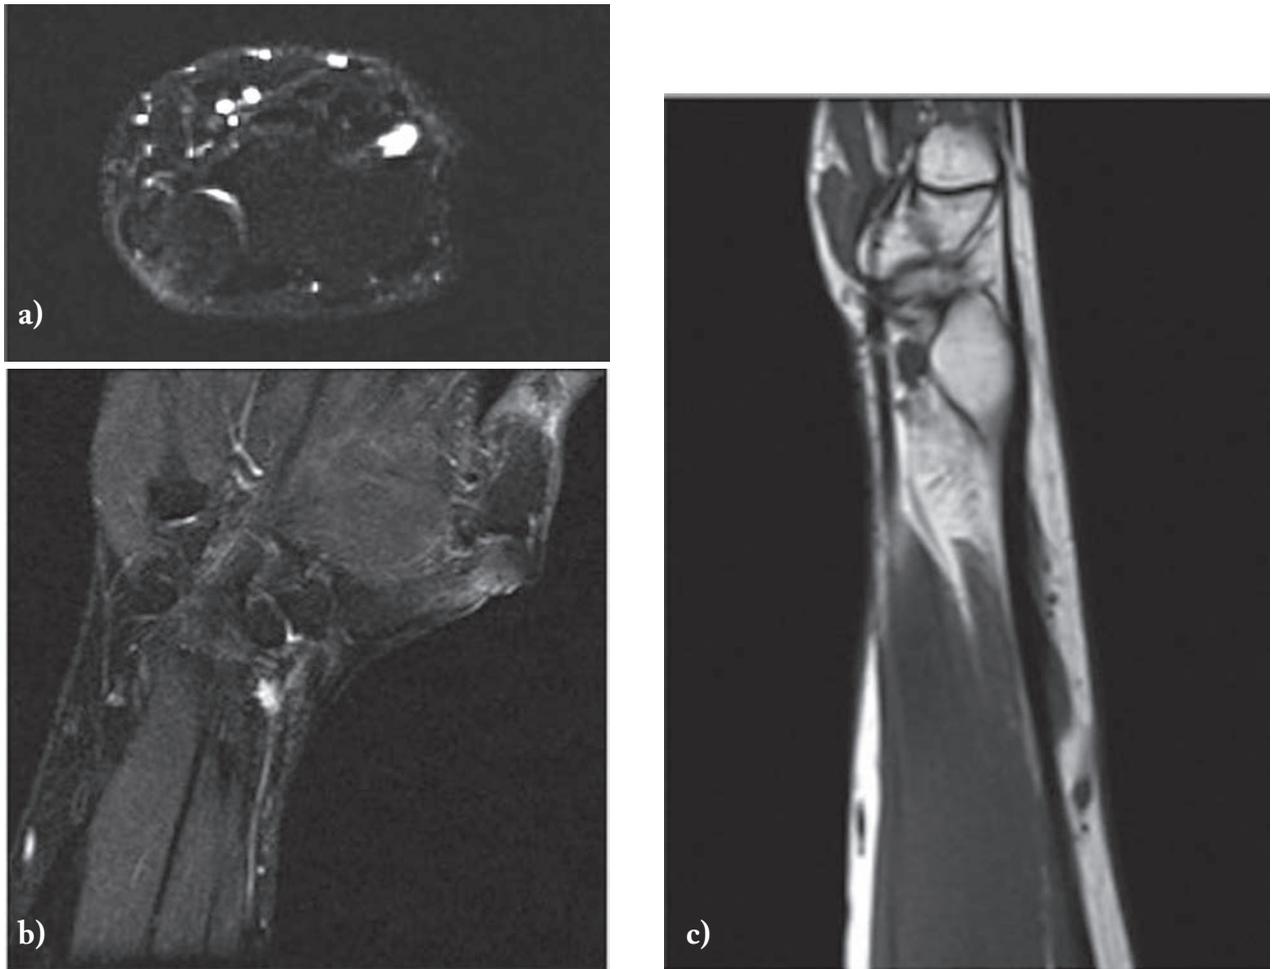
(a) FSE T2-w Fat-Sat axial (a) and coronal (b), T1-weighted sagittal (c): well-defined ovoid subcutaneous mass with an intermediate signal intensity (similar to that of muscle) on T1-weighted images and an intermediate-high signal intensity with a typical fascicular pattern on FSE T2-weighted images
